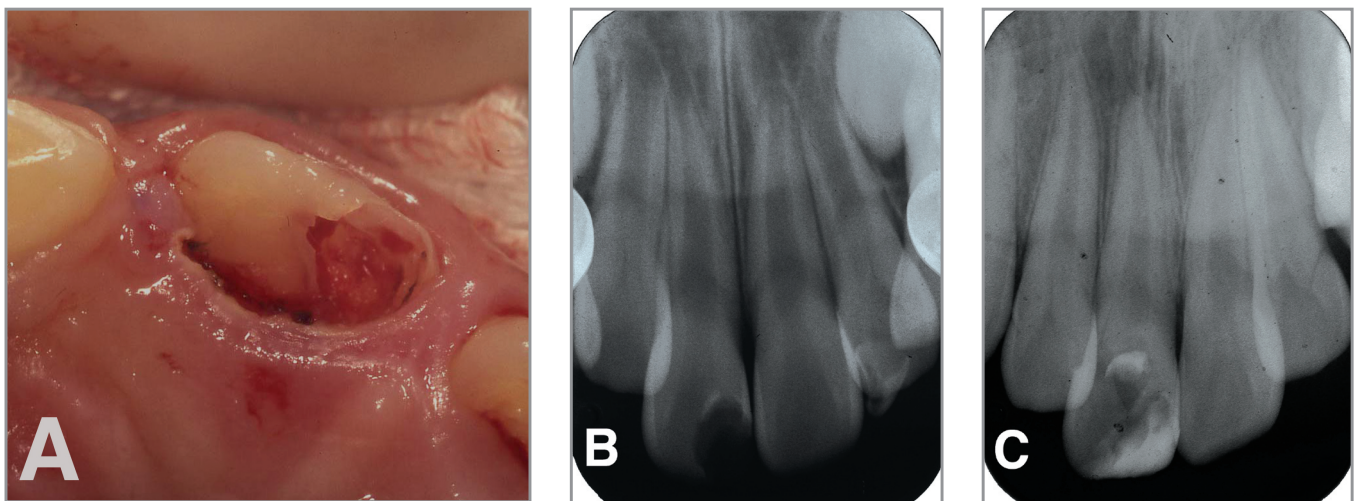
(a) Photograph of the palatal aspect after removal of soft tissues showing a large defect including enamel. (b) Periapical radiograph at age 11 years showing normal root formation (from Abe M et al¹⁸). (c) Periapical radiograph at 2 years 6 months after traumatic crown fracture and subsequent partial pulpotomy showing reparative dentin formation and apical maturation (age 13 years 8 months).
